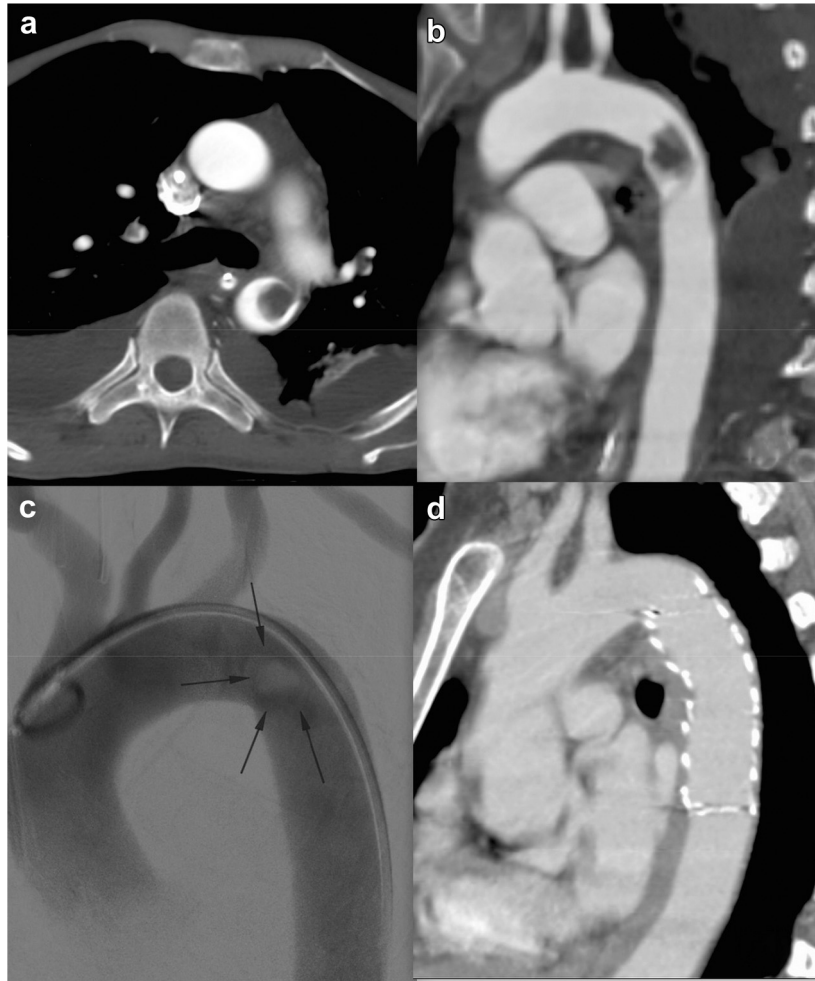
Type IIa primary aortic mural thrombus (PAMT). a and b, Preoperative computed tomography (CT) scan showing pedunculated thrombus distal to left subclavian artery. c, Intraoperative angiogram showing shadow of thrombus (*arrows*). d, Six-month follow-up CT scan showing complete exclusion of thrombus.
